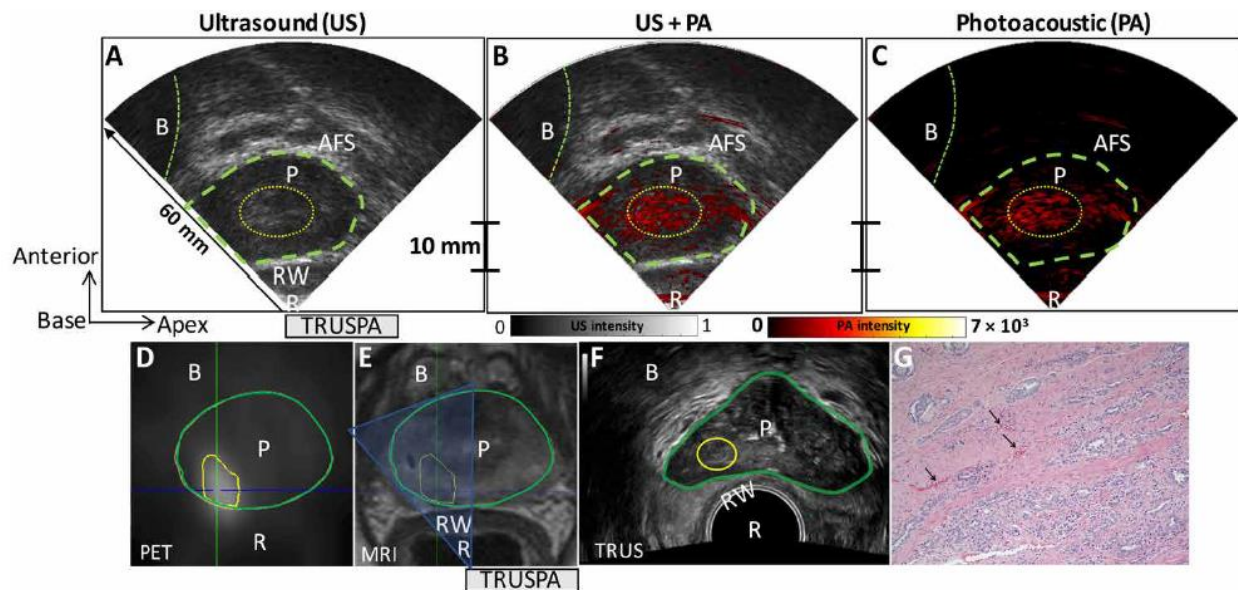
In vivo multimodal PET, MRI, TRUSPA imaging of the prostate in a patient with PCa (from Ref. [29]). In all images, the rectum (R), rectal wall (RW), bladder (B), anterior fibromuscular stroma (AFS), and prostate (P; green contour) are labeled. (A to C) Ultrasound (US) in grayscale, PA in red color scale, and co-registered US + PA images of human prostate obtained in vivo with the TRUSPA device. (D) Axial PET imaging showing PCa (yellow contour) using ^{68}Ga -labeled radioactive tracer targeting bombesin receptor on the PCa cells. (E) Axial MRI showing anatomical information of the prostate with yellow contour covering the extent of PCa identified using PET molecular imaging. (F) Axial TRUS image showing targeted region (yellow
